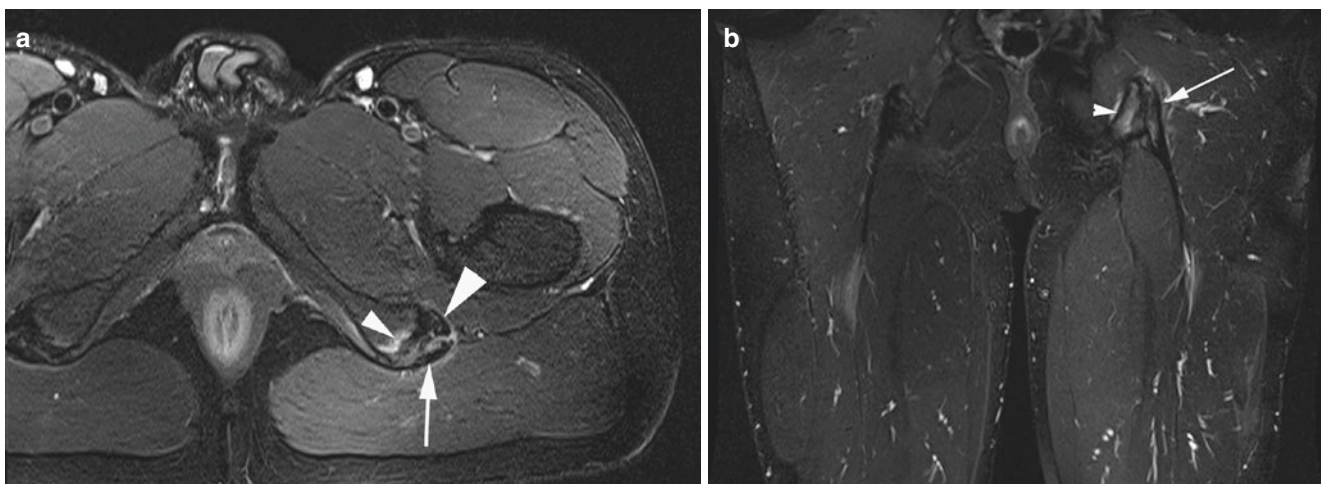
Tendinopathy. A 25-year-old soccer player with subacute hamstring pain. (a) Axial and (b) coronal T2FS MR images show left ischial subcortical bone marrow edema (small arrowhead), paratenon
